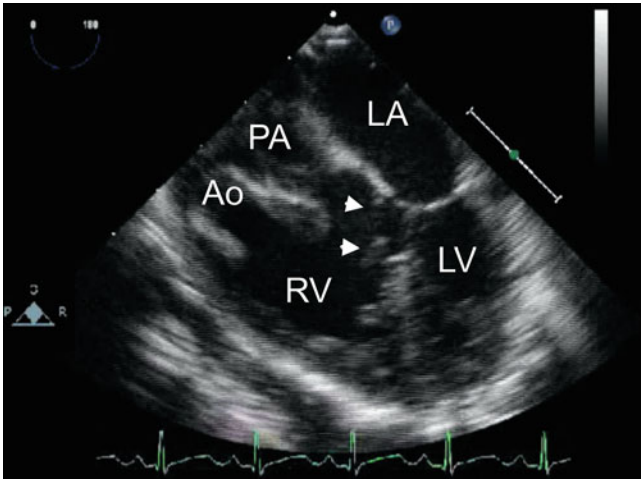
Transesophageal echocardiogram depicting a straddling mitral valve in a child with double outlet right ventricle. The image is obtained by transducer anteflexion after the mid esophageal four chamber view is obtained. Chordal attachments from the mitral valve are seen to straddle the ventricular septum and insert on the right ventricular aspect near the crest of the ventricular septum (*arrowheads*). The abnormal, side-by-side spatial orientation of the great arteries is shown. *Ao* aorta; *LA* left atrium; *LV* left ventricle; *PA* pulmonary artery; *RV* right ventricle
